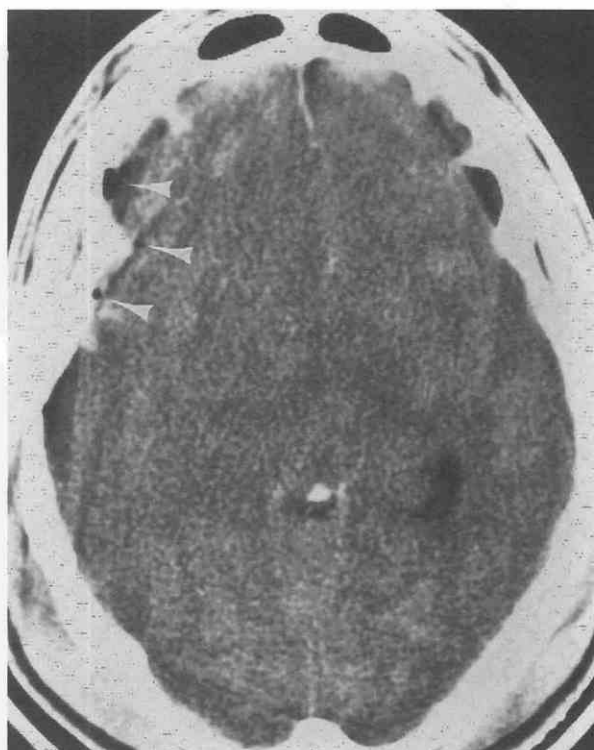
Axial CT scan shows effacement of basal cisterns, and third ventricle representing brain swelling. Note pneumocephalus overlying the right frontotemporal convexity (*arrowheads*).
